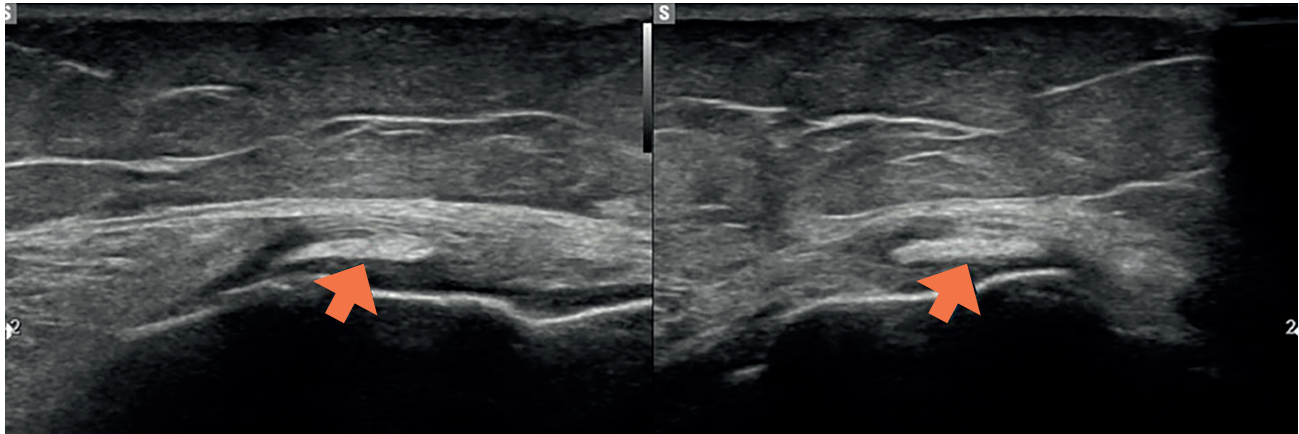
Right knee ultrasound. Mild bursitis. Calcification in the medial collateral ligament.
